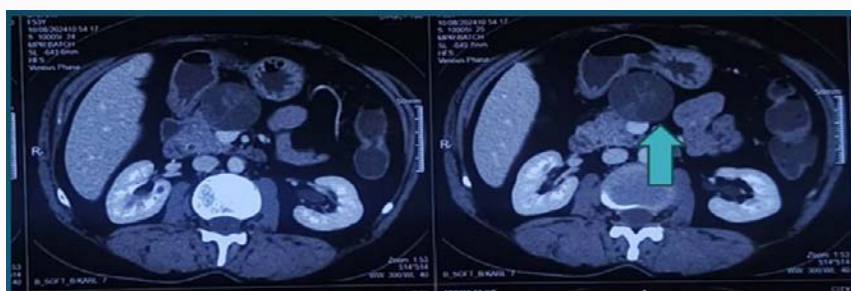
Axial CT scan image showing well defined round solid cystic lesion (arrow) noted involving head of the pancreas.
